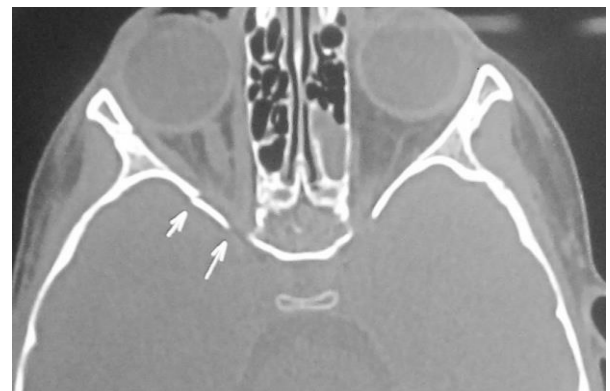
CT Orbit and Brain without contrast showing fracture Greater and Lesser wing of Sphenoid bone
